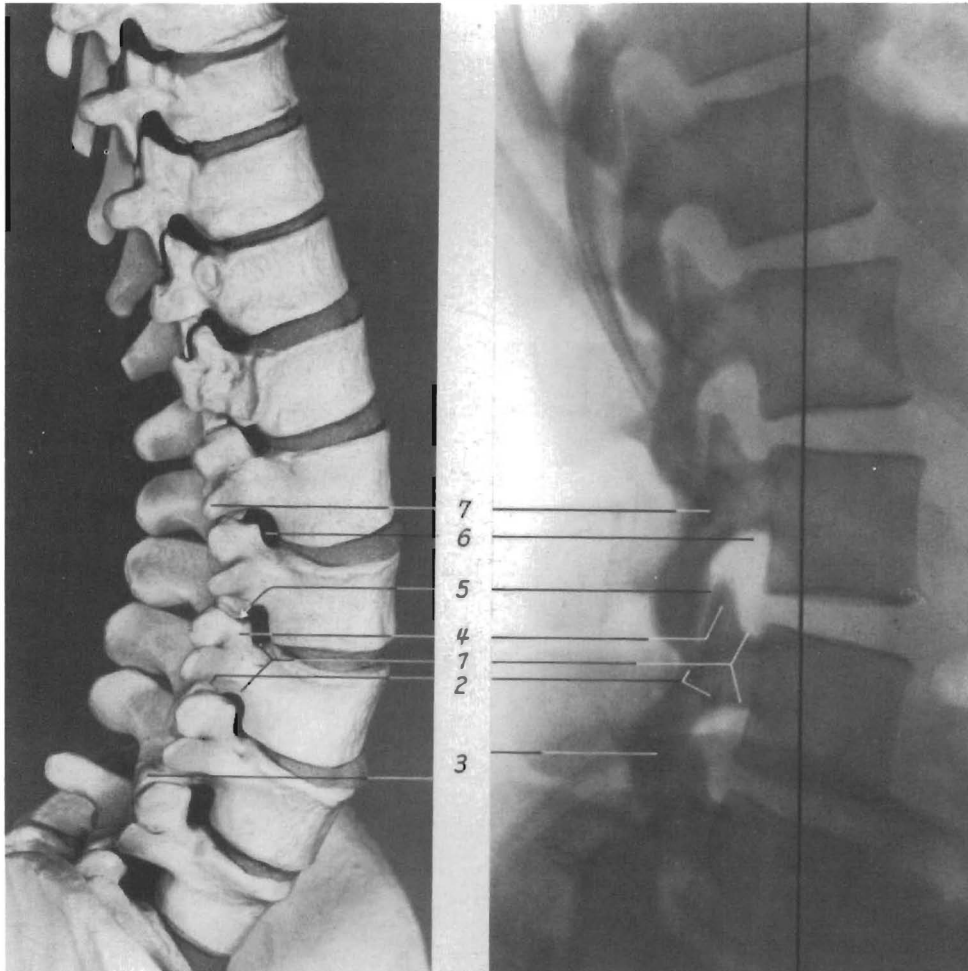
Comparison of the anatomical structures in the lateral view of the lumbar spine (model) and the X-ray. 1. Pedicle; 2. pars interarticularis; 3. lower articular process; 4. upper articular process; 5. joint space; 6. intervertebral foramen; 7. transverse process
